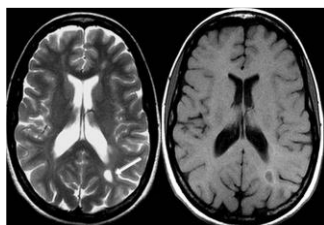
T1 and T2 MRI Images
